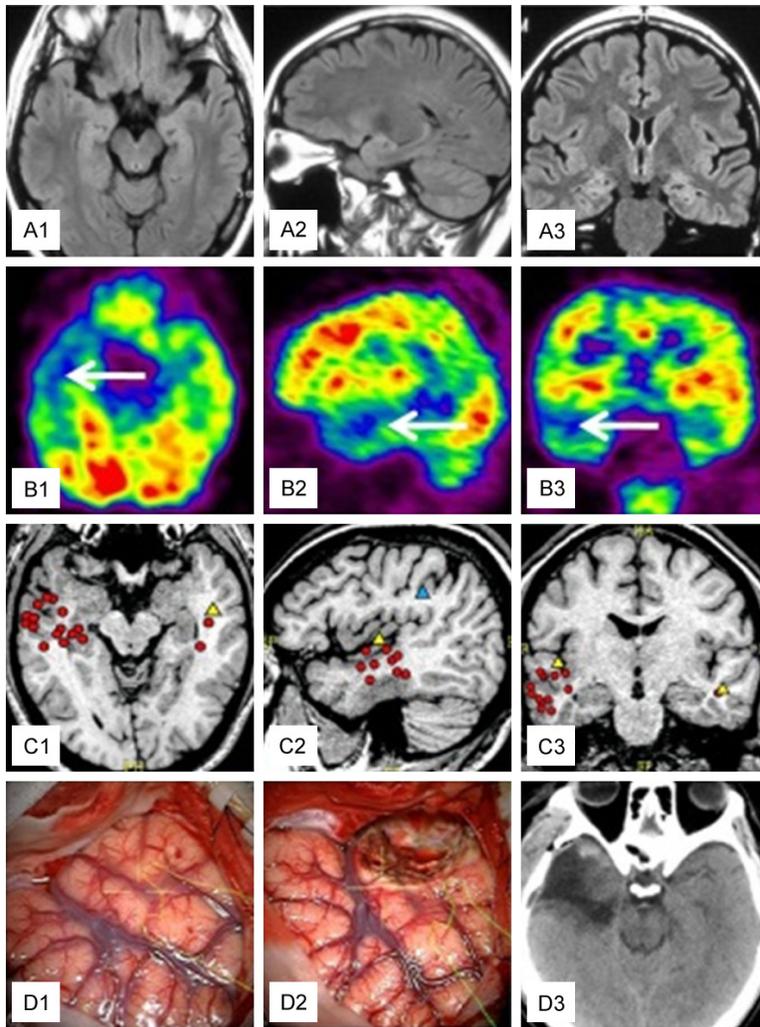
A. Lesions in the right temporal lobe were absent in the axial (A1), sagittal (A2), and coronal (A3) FLAIR sequences. B. Hypometabolism in the right temporal lobe is seen in the axial (B1), sagittal (B2), and coronal (B3) interictal FDG-PET scans (the arrows). C. Epileptogenic foci were localized in the right temporal lobe in the axial (C1), sagittal (C2), and coronal (C3) interictal MEG (red dots). D. (D1) No abnormalities in the right temporal cortex. (D2) The anterior temporal lobe and hippocampus were removed. (D3) The CT scan after operation.
